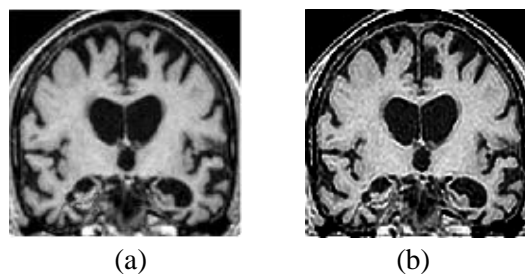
MRI Preprocessing (a) Original (b) Deblurred Image
